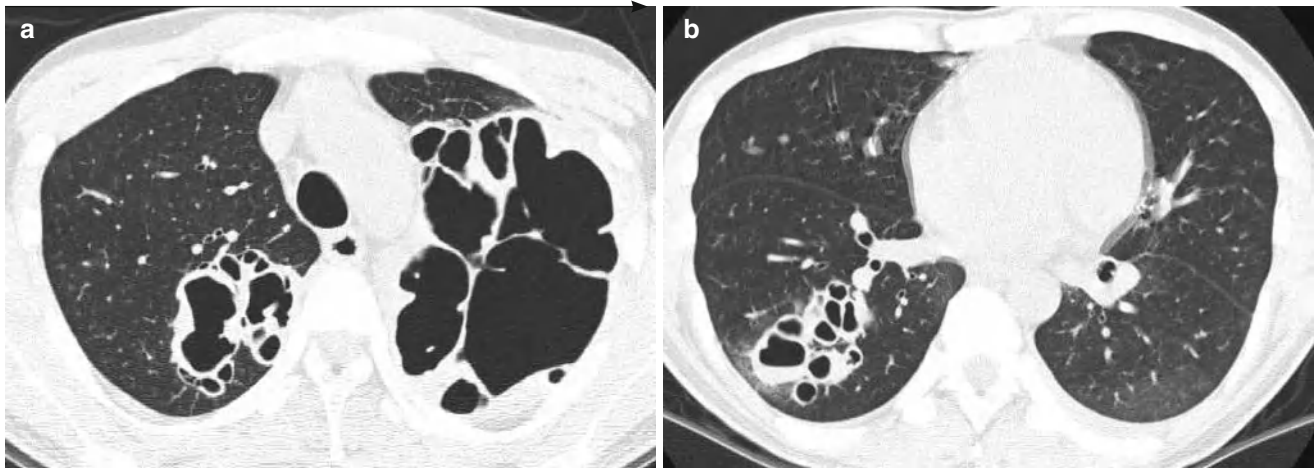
Multiseptated air-filled cystic lesions in both lungs in a 27-year-old man with HIV infection and *Pneumocystis jirovecii* pneumonia. (a, b) Lung window images of CT scans (2.5-mm-section thickness) obtained at levels of aortic arch (a) and right inferior pulmonary
